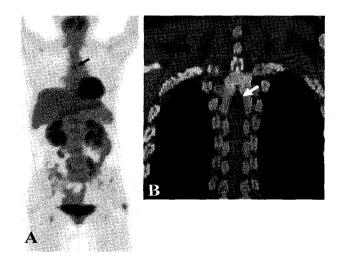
PET/CT scan. A. Maximum intensity projection of torso shows an ovoid tumor with increased FDG uptake at the 4th thoracic spine level (arrow). B. Magnified coronal scan of the tumor-bearing region shows a small intradural tumor with increased FDG metabolism (SUV = 5.1 max and 4.3 on initial scan and 2-h delayed scan, respectively).
